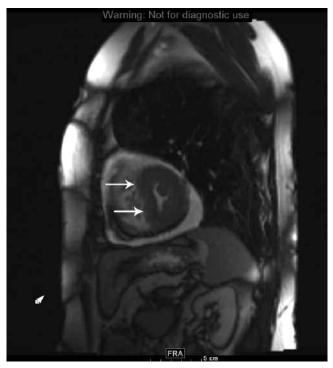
Magnetic resonance imaging short axis view demonstrating intraventricular diastolic flattening (D-sign; arrows).
